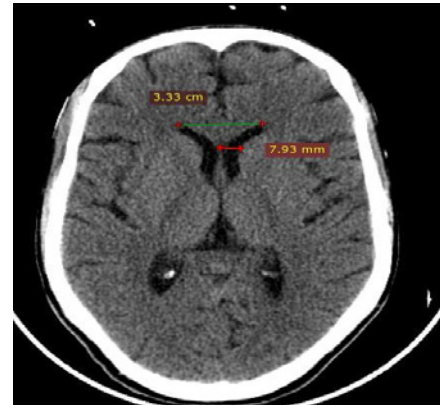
Axial CT image of the brain shows the maximum distance between the tip of frontal horns and maximum frontal horn width (captured at radiology department 2019).
